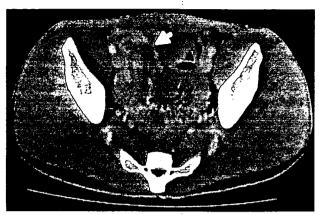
Abdominal CT showing mild bowel wall thickening and large round mass in the ileocecal region (white arrow).
